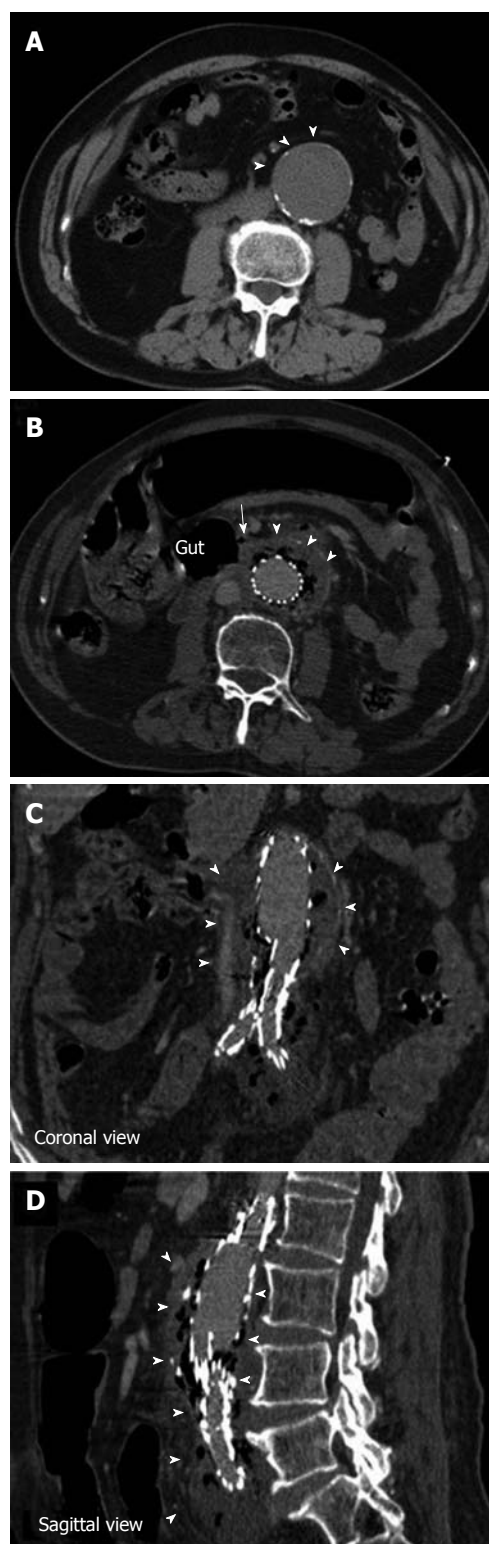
Abdominal computed tomography scans of the patient. A: The abdominal aortic aneurysm before stent-graft implantation (arrowheads); B: The aortoduodenal fistula (arrow); B-D: The necrotic tissue and associated gas formation (arrowheads).
